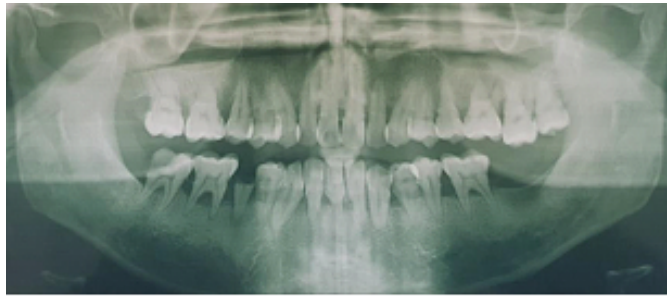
Full mouth radiograph. (Source: Author's own work).
